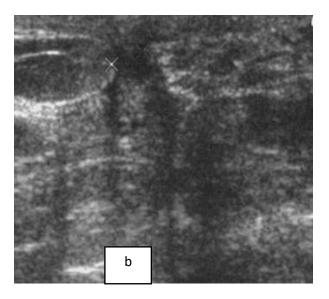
Disappearance of the mass on mammogram (a) and breast ultrasound (b) one year after antituberculosis treatment.
